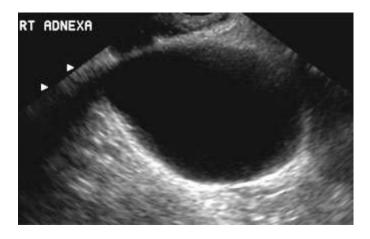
Simple ovarian cyst - (www.ultrasoundimagegallery.com)
